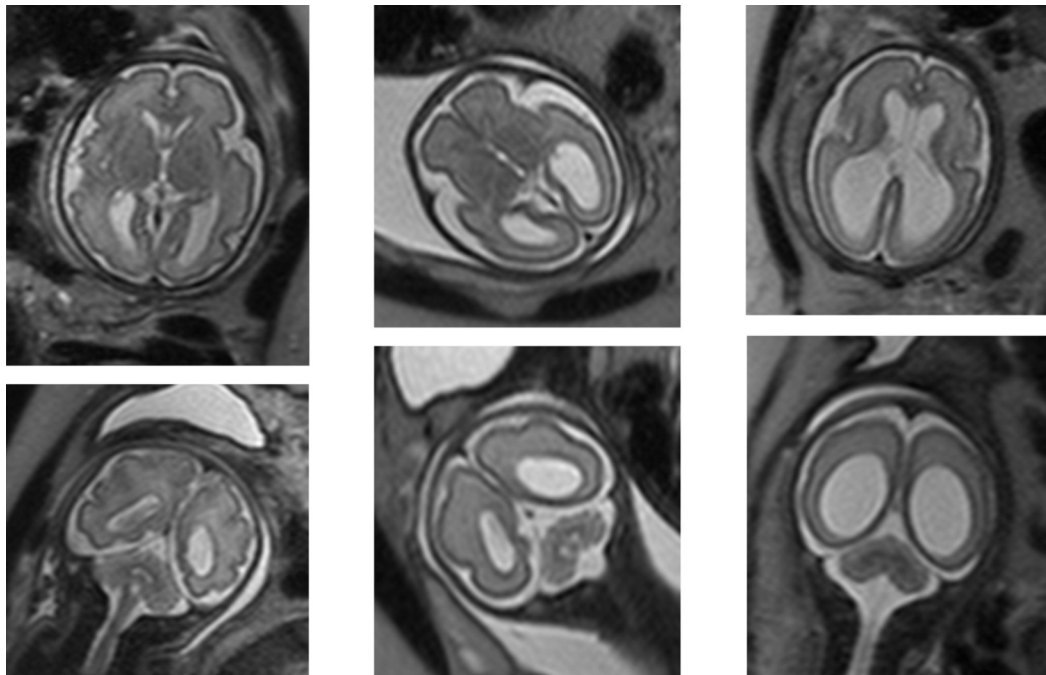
T2-weighted axial and coronal images: mild (first column), moderate (middle column) and severe (last column) ventriculomegaly. The atrial diameters and gestational ages are respectively 11, 13 and 24 mm and 29, 27 and 28 weeks.
